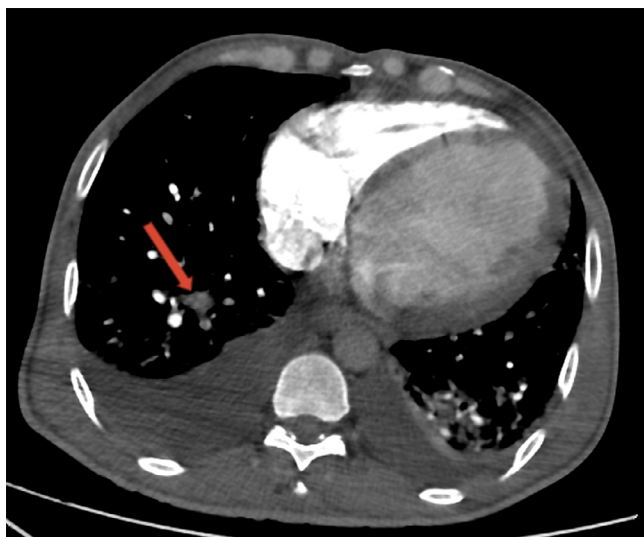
Computed tomography pulmonary angiography (CTPA) showing pulmonary embolism (PE) in the segmental branch of the right lower lobe pulmonary artery (A) Axial view (B) Coronal view.
